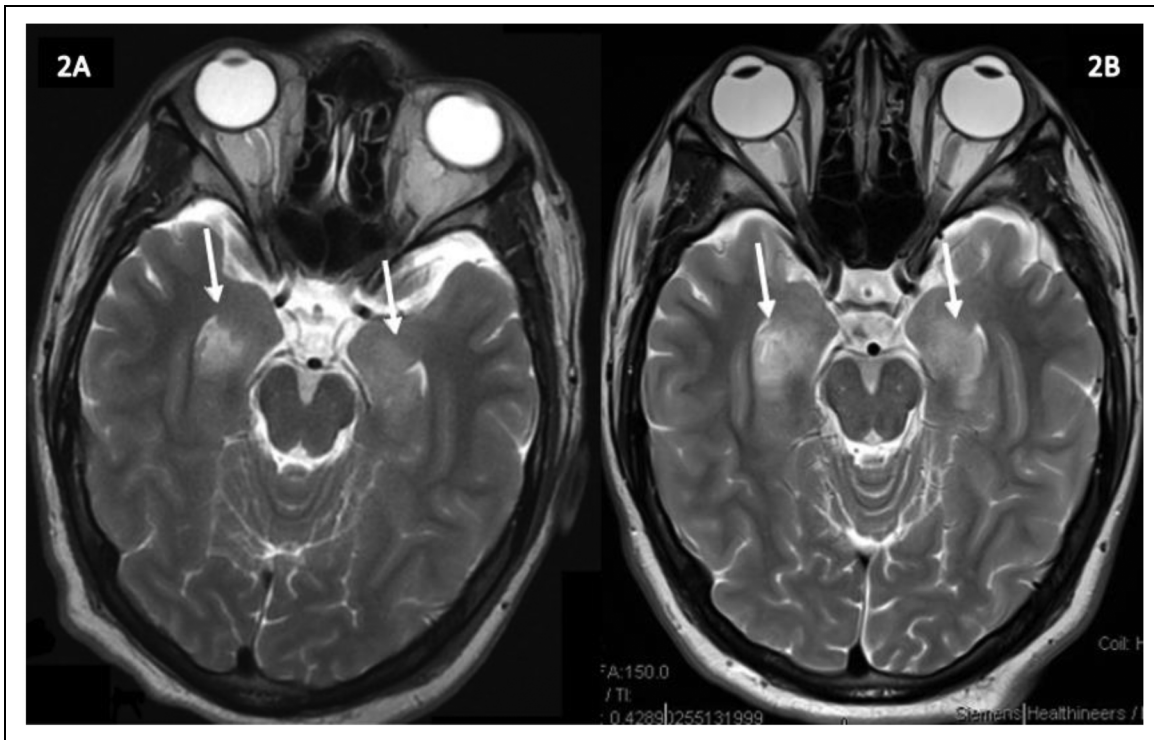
A (Left): Axial T2 propeller from HD2. Axial T2 imaging from HD2 demonstrating signal abnormalities with more extensive signal changes on the left versus right, demonstrated by white arrows. B (Right): Axial T2-weighted image from HD5. Axial T2 imaging from HD5 demonstrated enhanced signal bilaterally, worse on right side versus left, demonstrated by white arrows.
